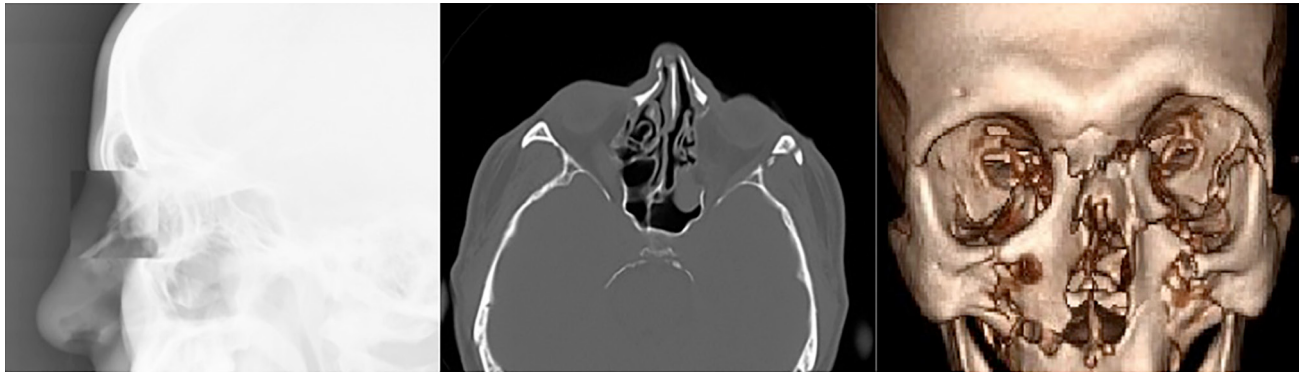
A 48-year-old man with bilateral, comminuted nasal fracture at level III and accompanying fractures orbital, zygoma, maxilla fracture (Images of radiography, axial plane of maxillofacial computed tomography, and three-dimensional computed tomography).
